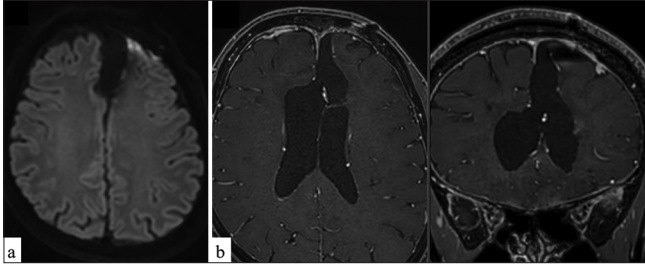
(a) Postoperative diffusion-weighted image (DWI) showing no acute cerebral infarction. (b) Postoperative contrast-enhanced T1 image showing no residual tumor.
